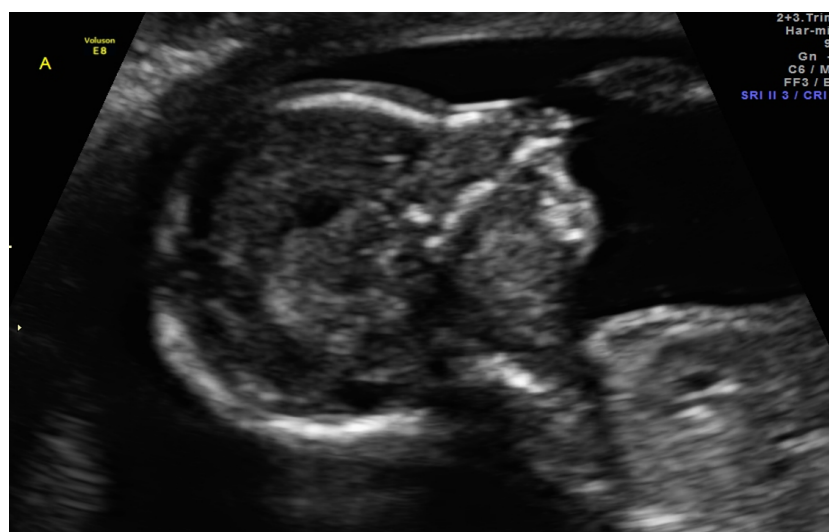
Ultrasound evaluation of the affected fetus's face profile at 18 weeks of gestation, evidencing an apparent retrognathia.
